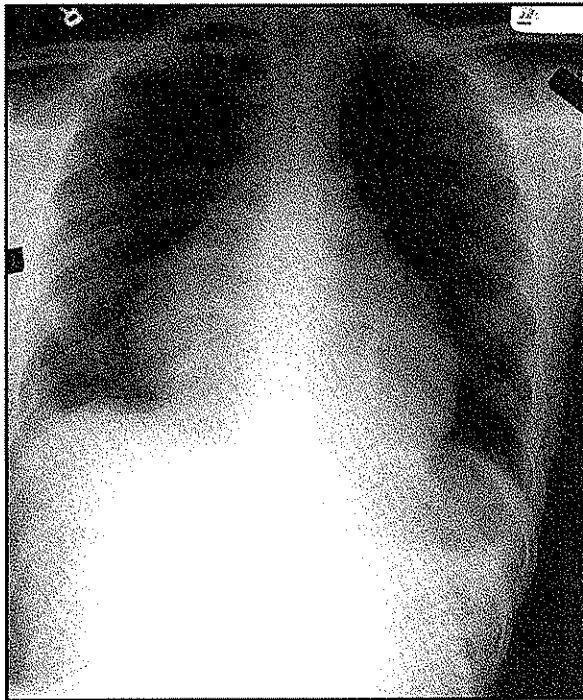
Chest radiograph from Patient 1, demonstrating large pericardial effusion; this eventually resolved with anti-inflammatory therapy.
